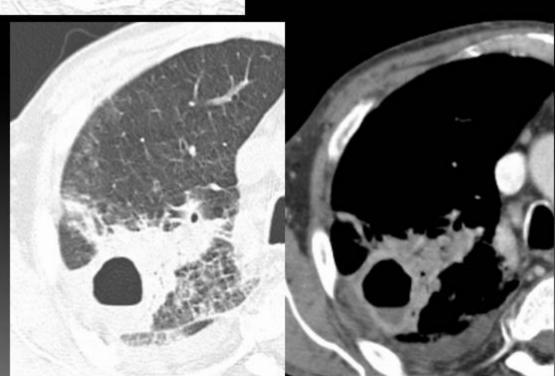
Woman, 51 years old with dyspnea, fever, productive cough and hemoptysis. Thoracic CT discloses consolidation with two cavitations. These have air fluid level (lung abscesses).
